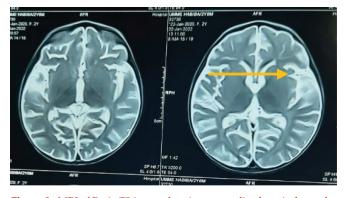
MRI of Brain T2 image showing generalized cortical atrophy
